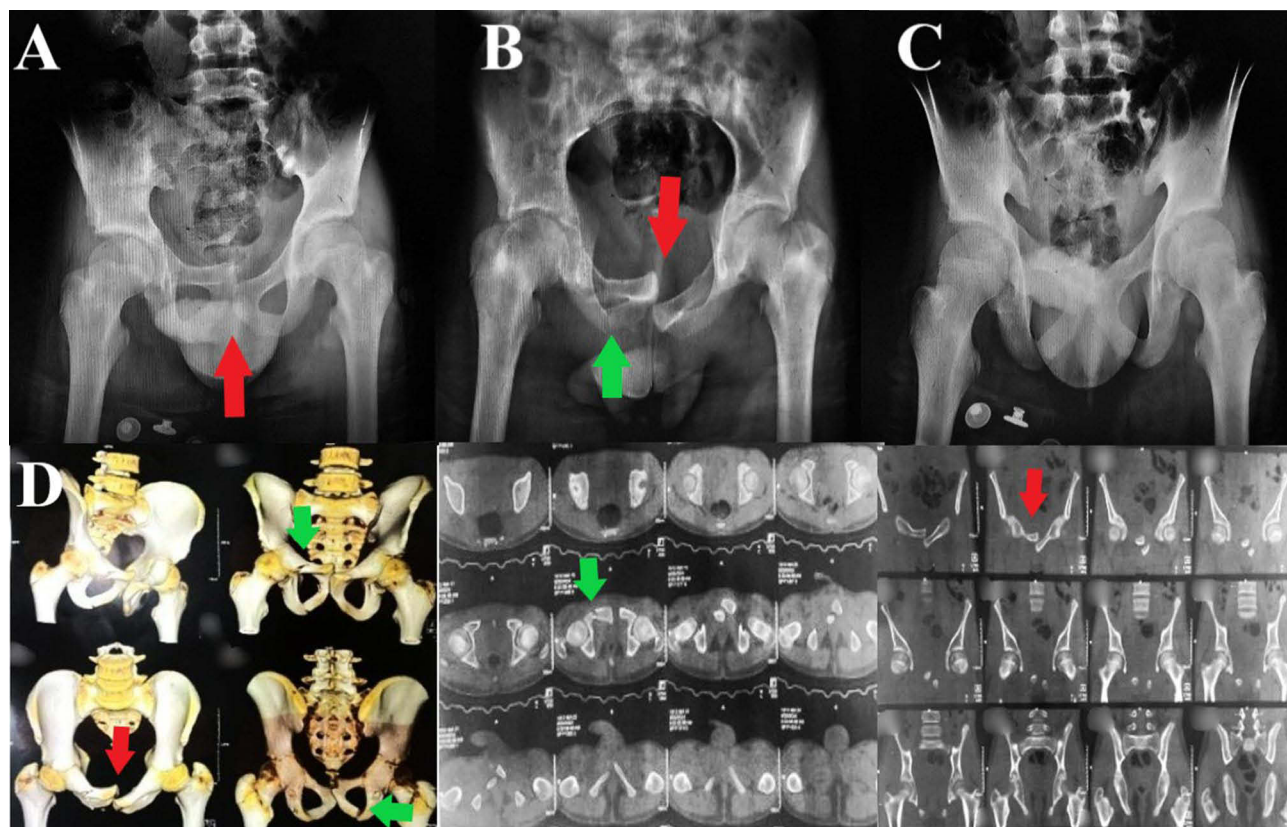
Preoperative imaging studies, plain radiographs: (A) anteroposterior view. (B) Inlet view. (C) Outlet view. (D) computed tomography different scans. The red arrowheads indicate the locked symphyseal disruption and the green arrowheads indicate the right pubic rami fractures.
